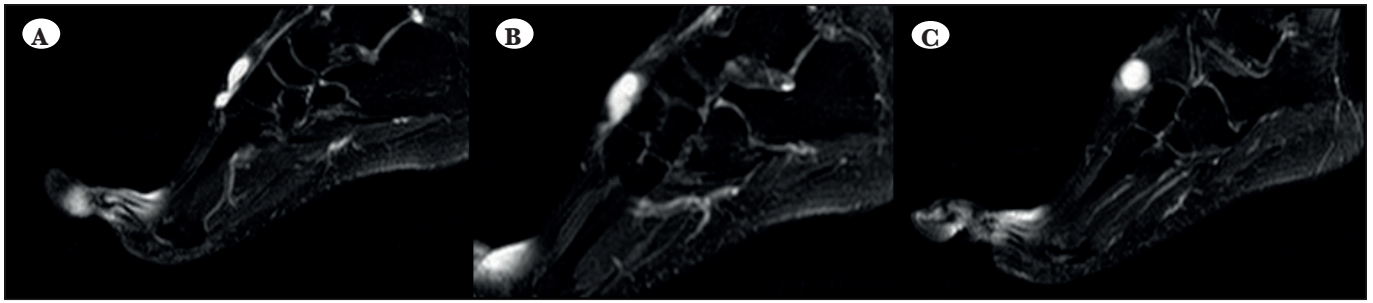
A,B,C The sagittal MRI views of the ganglion cyst.
